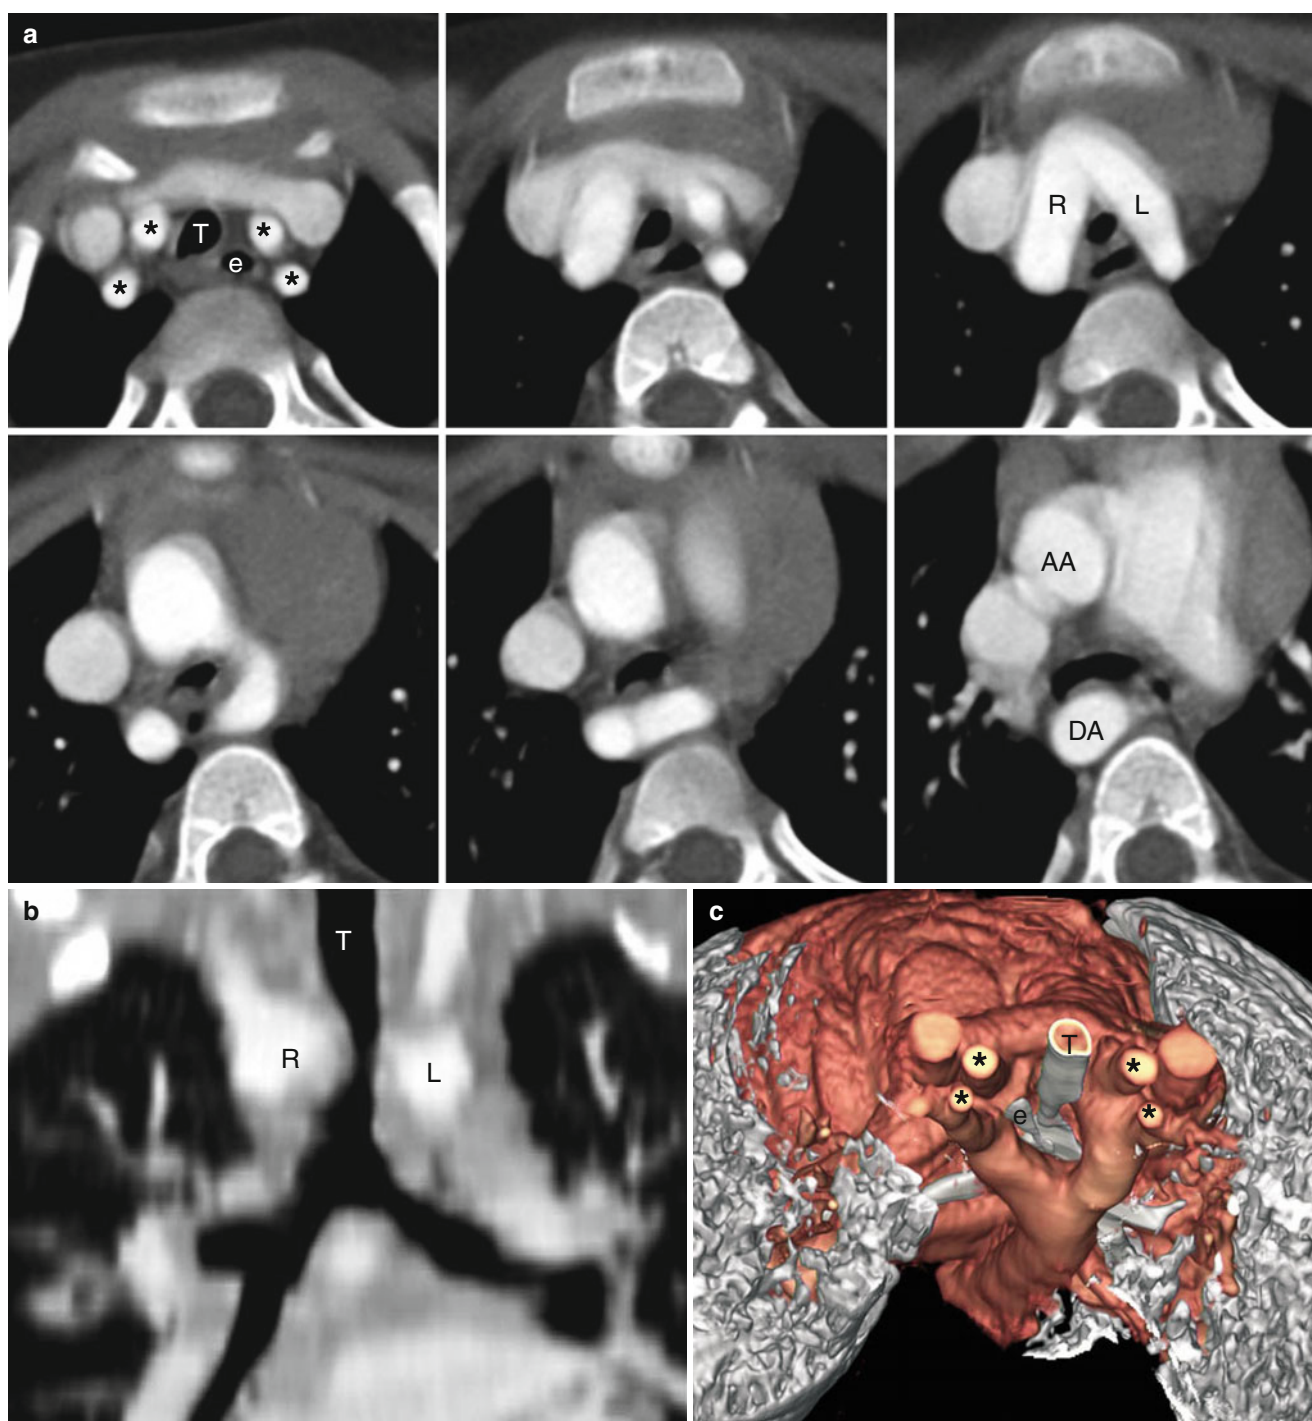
Complete double aortic arch in a 5-year-old boy. (a) Axial CT images show a double aortic arch with both arches patent, which completely encircle the trachea (T) and the esophagus (e). (b) Coronal reformatted image shows severe focal stenosis of the trachea (T) due to compression of both arches. The right aortic arch (R) is larger in size
